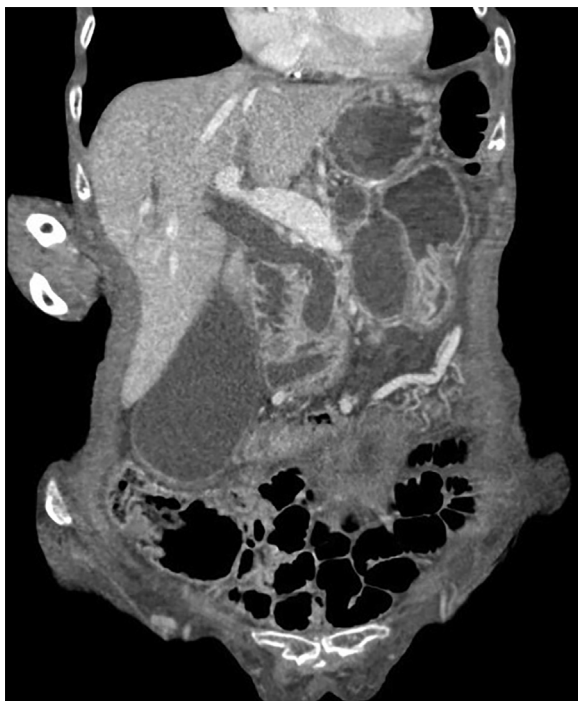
CT scan demonstrating a distended gallbladder and distended stomach.
